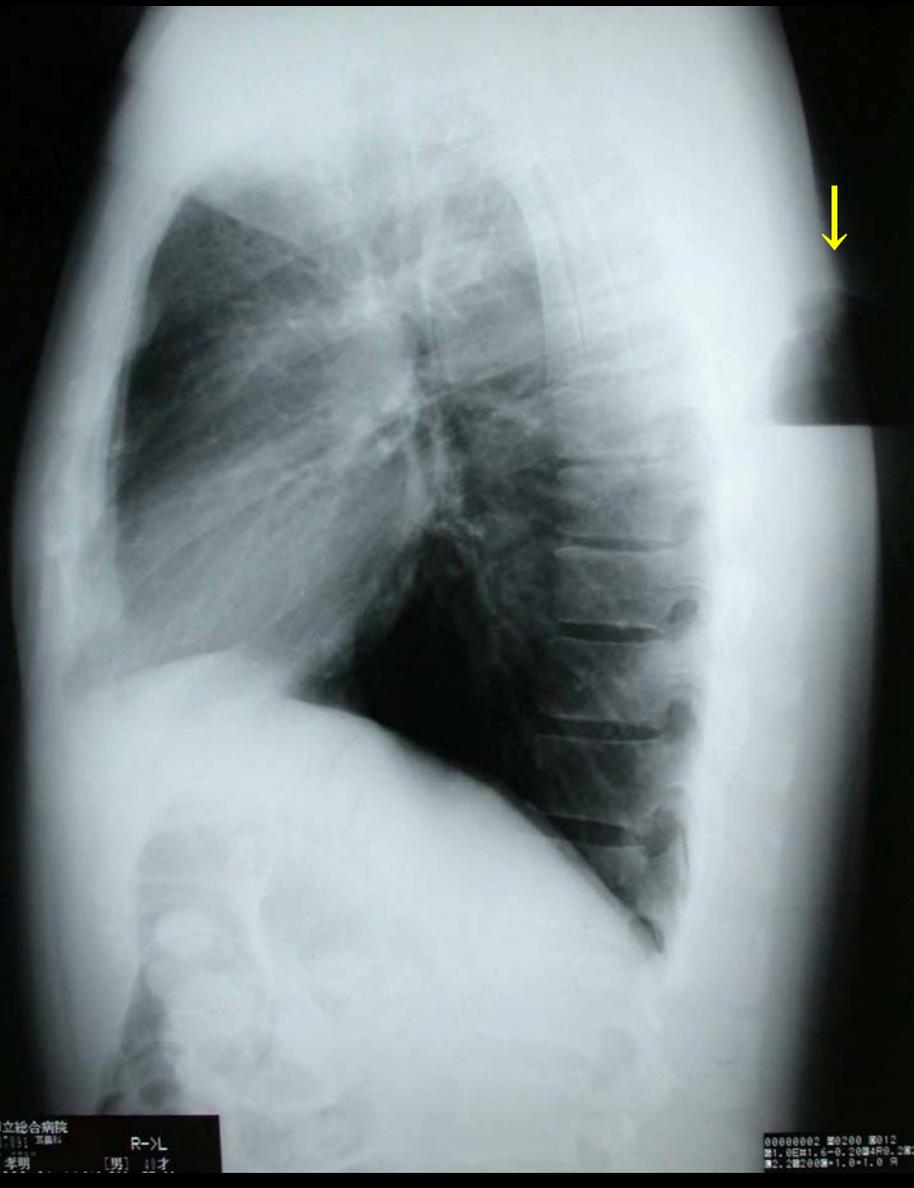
Chest radiograph revealed a niveau like gas formation (arrow)
